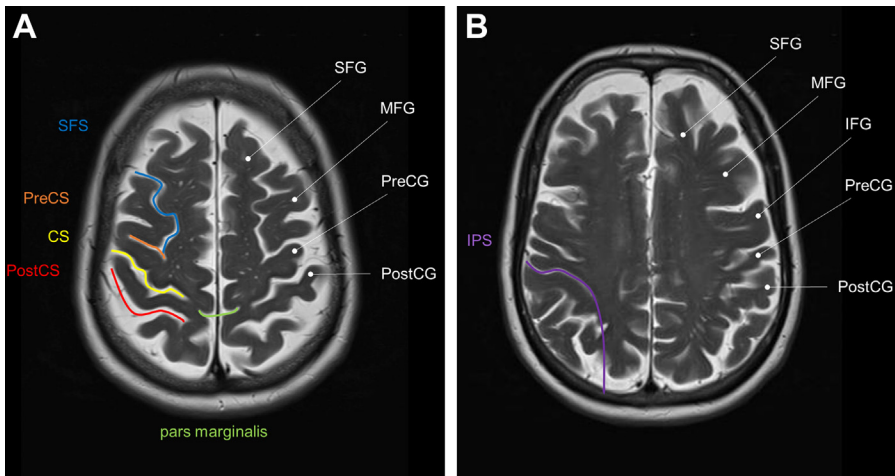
Axial T2-weighted spin-echo images at the level of the (A) central sulcus and (B) intraparietal sulcus. Labeled gyri include the superior frontal gyrus (SFG), middle frontal gyrus (MFG), precentral gyrus (PreCG), and postcentral gyrus (PostCG). Labeled sulci include the superior frontal sulcus (SFS, blue), precentral sulcus (PreCS, orange), central sulcus (CS, yellow), postcentral sulcus (PostCS, red), pars marginalis of the cingulate sulcus (green), and intraparietal sulcus (IPS, purple).
